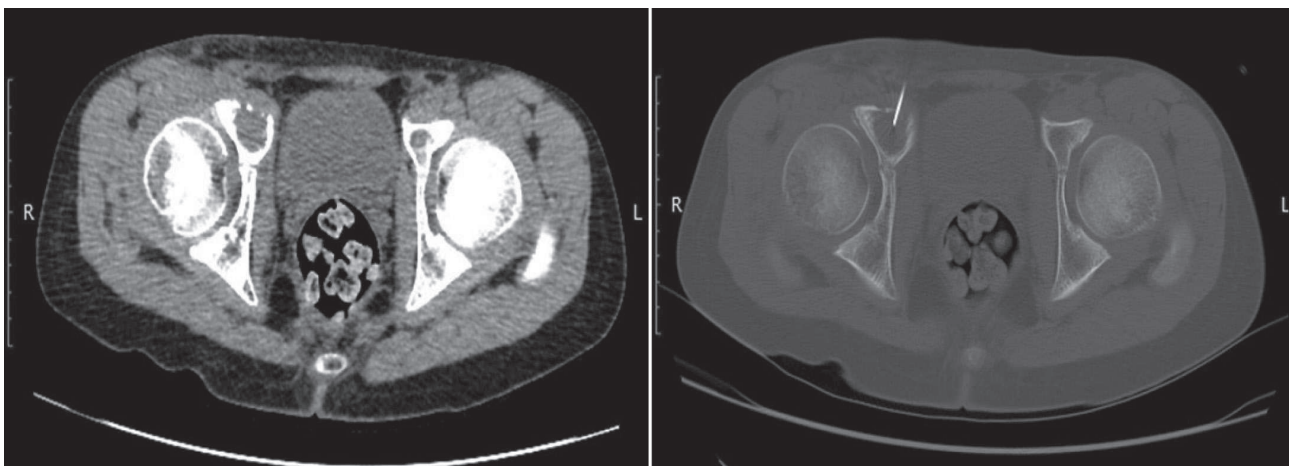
Computed tomography (CT) reveals an osteolytic lesion with a defined sclerotic transition zone of the right acetabulum.
